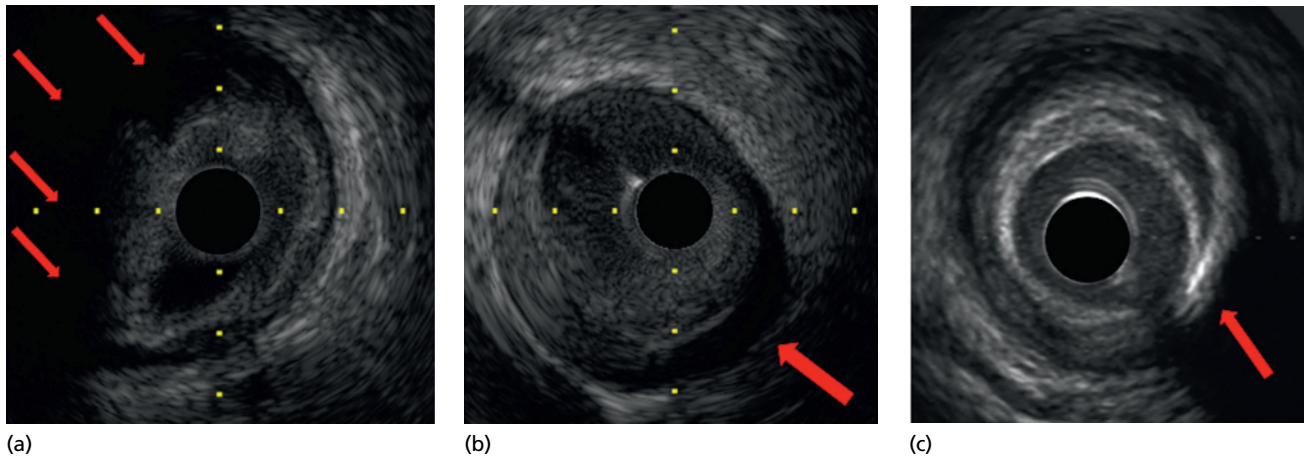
IVUS features of vulnerable plaques. (a) Attenuated plaque (red arrows): a hypoechoic area with deep ultrasonic attenuation despite the absence of bright calcium. (b) Echolucent plaque (red arrows): plaque echolucency characterized by an intraplaque zone of absent or low echogenicity. (c) Spotty calcification: the presence of lesions 1 to 4 mm in length containing an arc of calcification of $<90^\circ$.
